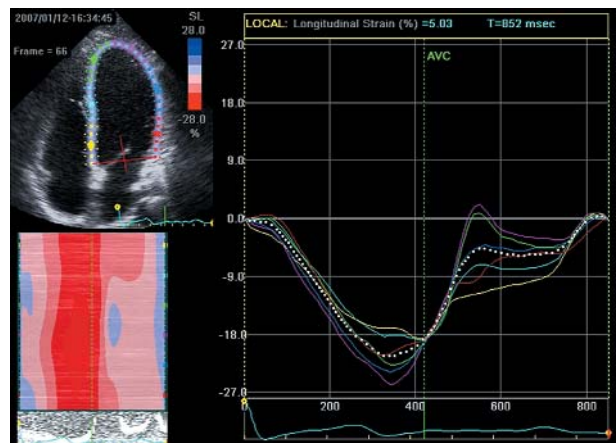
Four-chamber apical view; a quantitative analysis of myocardial longitudinal strain using speckle tracking echocardiography. Measurements correspond to location in Figure 1 (adopted from: Chrzanowski Ł, Lipiec P, Krzemińska-Pakuła M, et al. Echocardiographic evaluation of left ventricular strain with the use of tissue Doppler technique and speckle tracking echocardiography. *Polski Przegląd Kardiologiczny* 2007; 9: 195-202)
